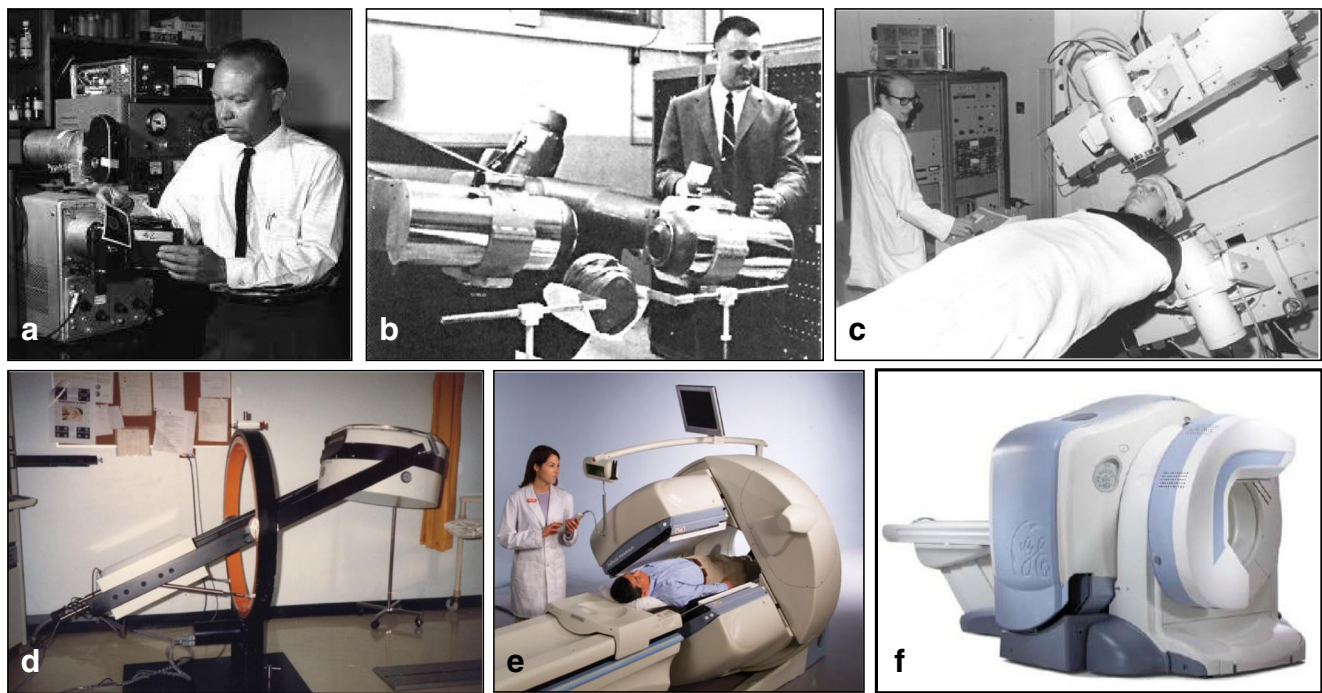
The evolution of SPECT. a Hal Anger, inventor of the gamma camera (1958) and other tomographic systems (1967) [10, 19]; b David Kuhl with an early tomographic scanner (1968) [6, 8]; c Ian Keyes with the Aberdeen section scanner (1972) [9]. d The original cantilevered GE
